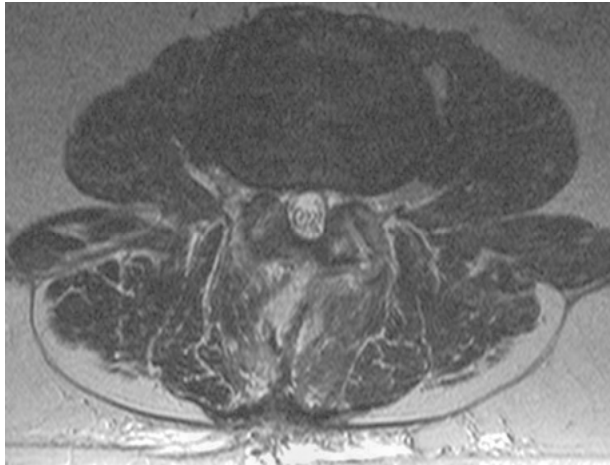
T2-weighted axial MRI showing L3-L4 segment after decompression.
